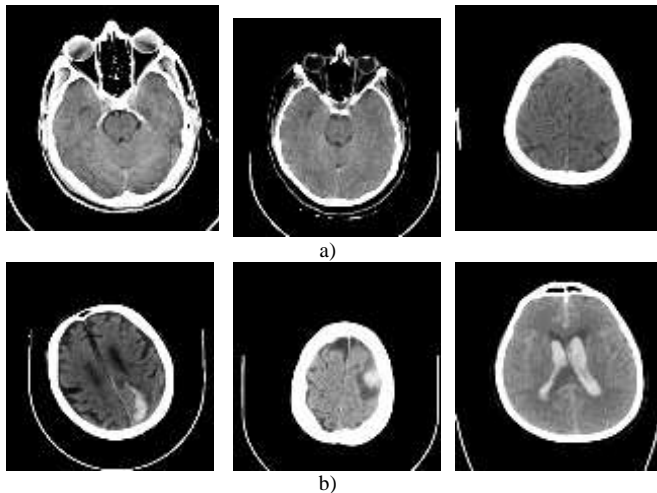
Some CT brain images of (a) no stroke (b) brain stroke in the dataset
